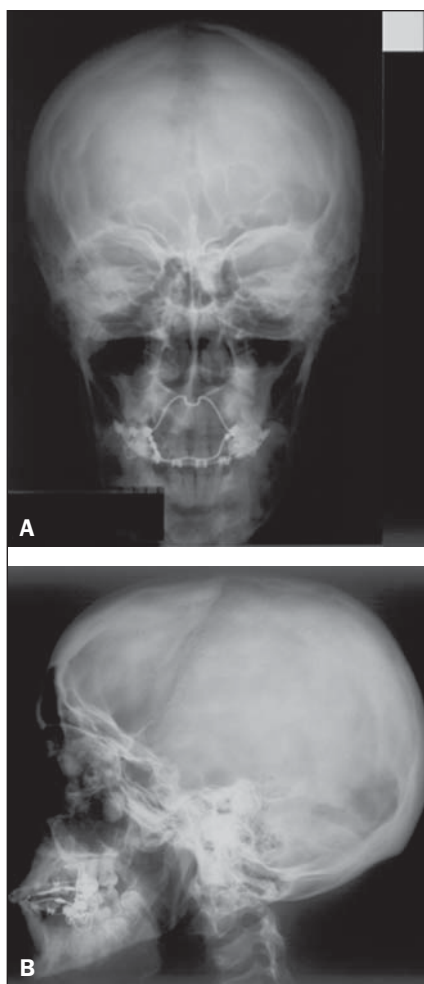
Skull radiography. Posteroanterior (A) and lateral (B) views.
